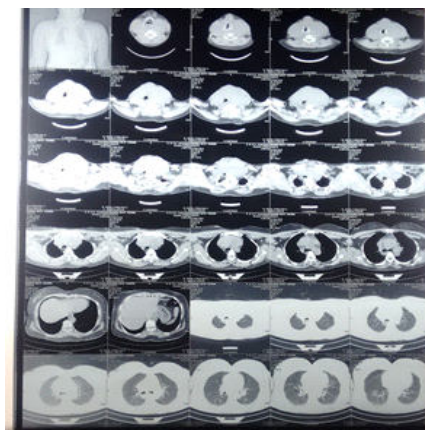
CT scan to delineate the margins
